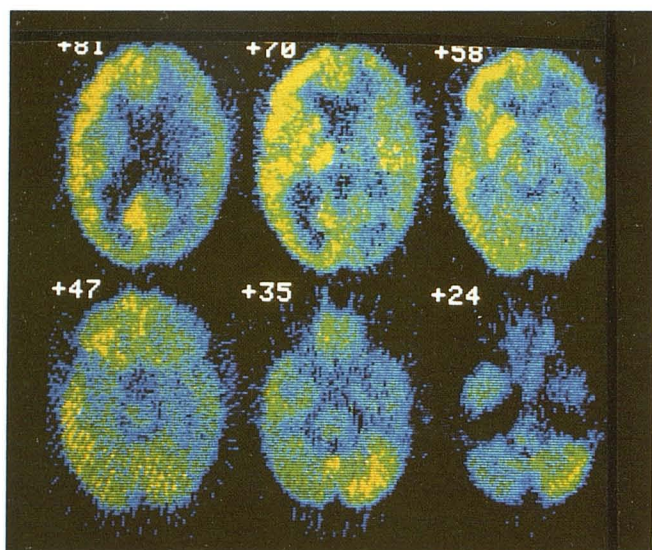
Case 13: chemotherapy-induced necrosis. PET-FDG scans show diffuse hypometabolism of entire right cerebral hemisphere (green, blue). Note that cortex of right cerebellar hemisphere is normometabolic (yellow), while left cerebellum is hypometabolic (scans 35 and 24); this phenomenon is referred to as “crossed cerebellar diaschisis.” (Right side of patient is on right side of image.)
